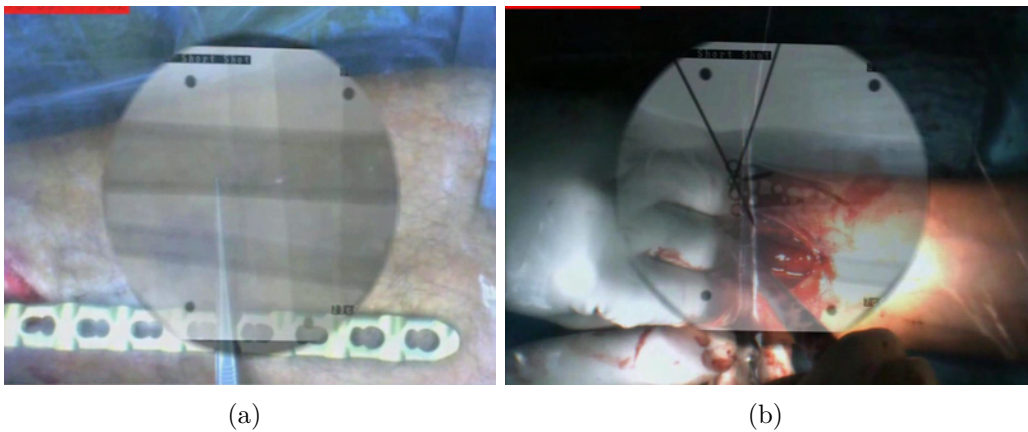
(a) The X-ray and video image overlay is used to check if the length of a bridge plate is suitable; (b) The hand of a surgeon is within the X-ray beam, as it is visualized within the X-ray image area of the overlay.
